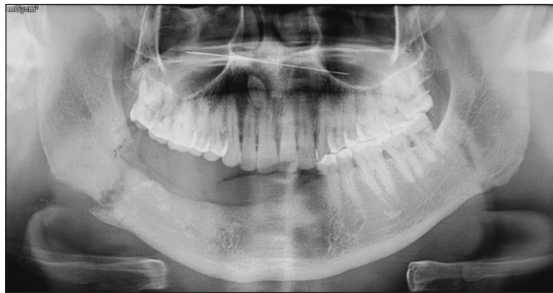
Panoramic radiograph showing pathological fracture of the right body of mandible during follow-up after removal of necrotic bony tissue
